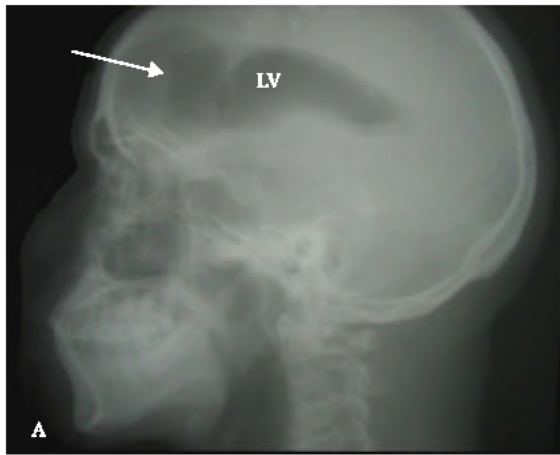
Lateral skull radiograph showing pneumocephalus in the region of the frontal lobe and the lateral ventricles
